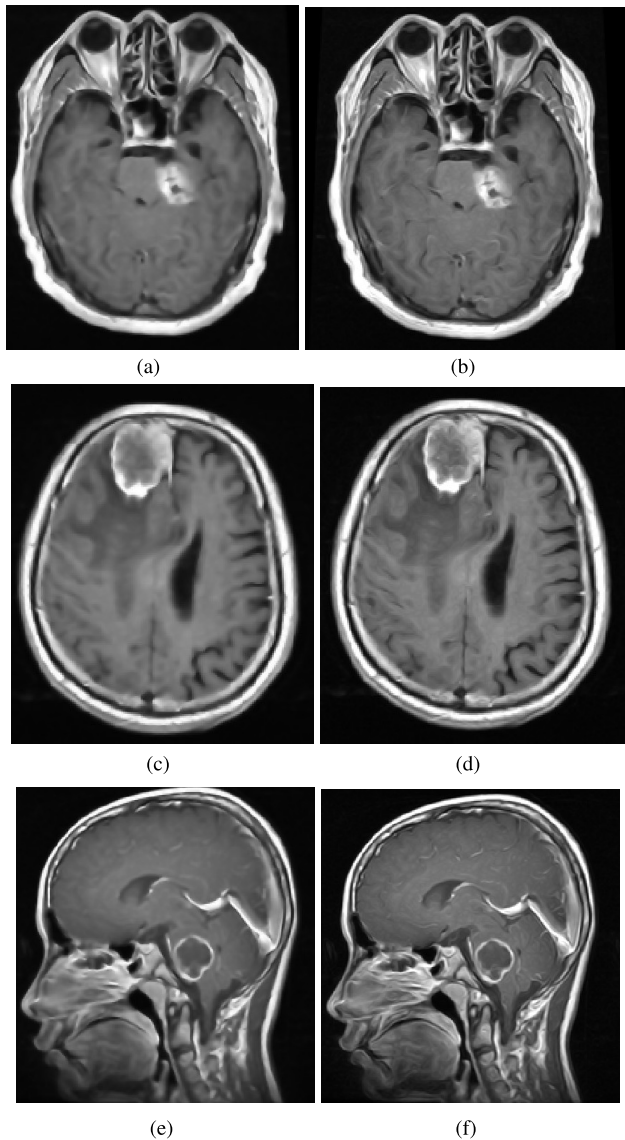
Enhanced the clarity of brain MRI: comparison of original and filtered images on the axial, sagittal and coronal planes. The first row shows the original and filtered images in the axial planes. The second row shows original and filtered images in the sagittal planes. The third row shows original and filtered images in the coronal planes.
